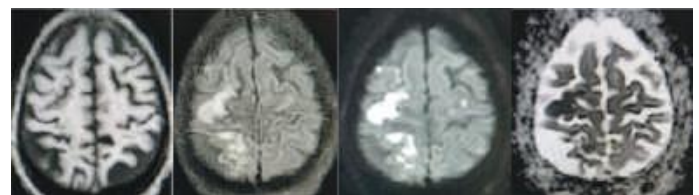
T1, Flair, DWI & ADC images showing Hyperintensity in Flair with diffusion restriction and low ADC values suggestive of Acute Infarct
